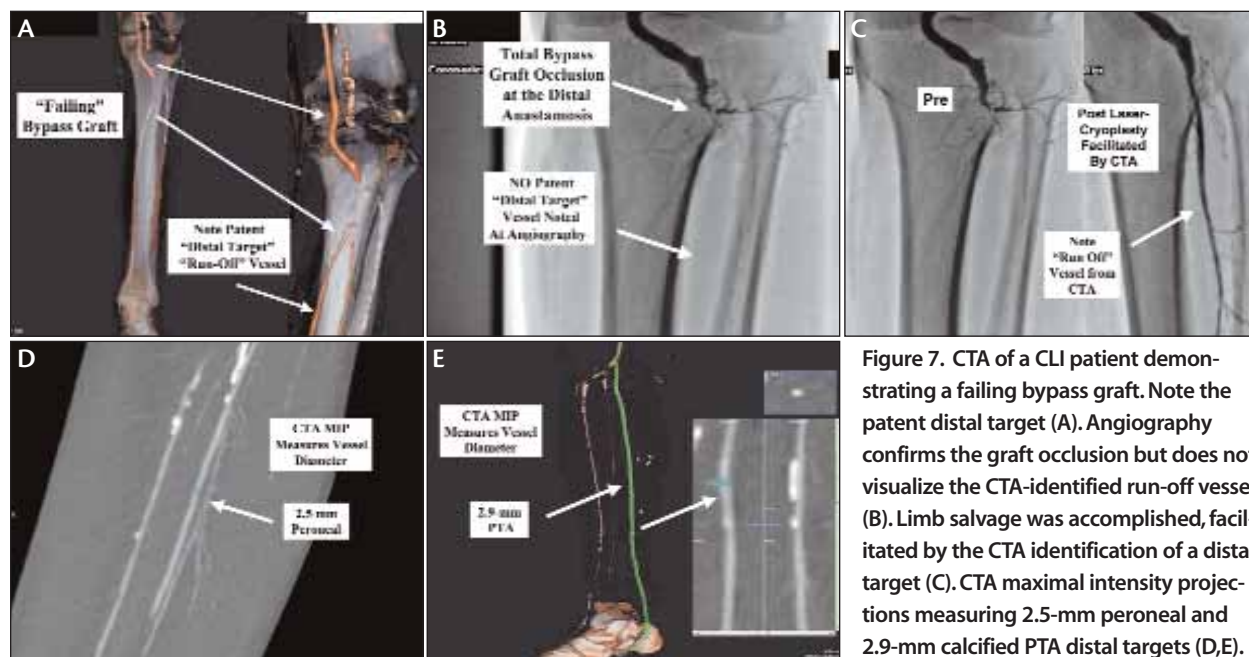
CTA of a CLI patient demonstrating a failing bypass graft. Note the patent distal target (A). Angiography confirms the graft occlusion but does not visualize the CTA-identified run-off vessel (B). Limb salvage was accomplished, facilitated by the CTA identification of a distal target (C). CTA maximal intensity projections measuring 2.5-mm peroneal and 2.9-mm calcified PTA distal targets (D,E).
